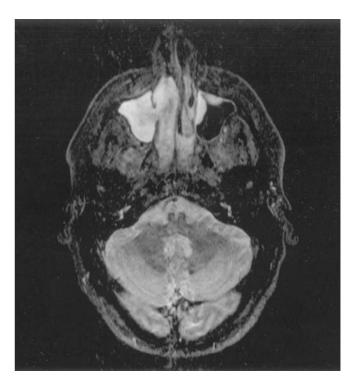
Axial STIR MRI scan showing high signal intensity of maxillary component, and mixed signal intensity of nasal/naso-pharyngeal component
